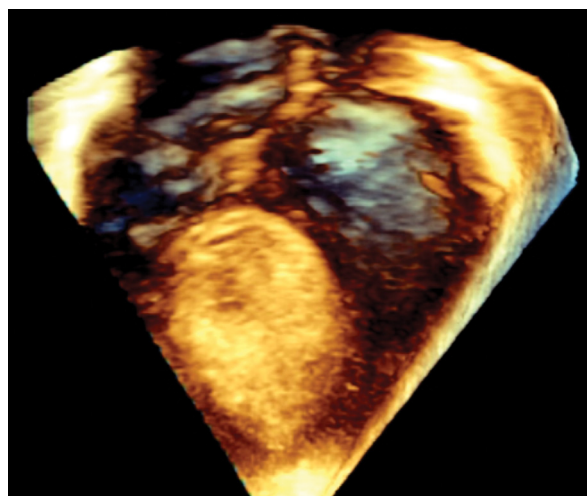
Three-dimensional echocardiography, four-chamber projection. A tumour protruding into both ventricles, not obstructing the blood flow within the ventricles is seen in the interventricular septum
